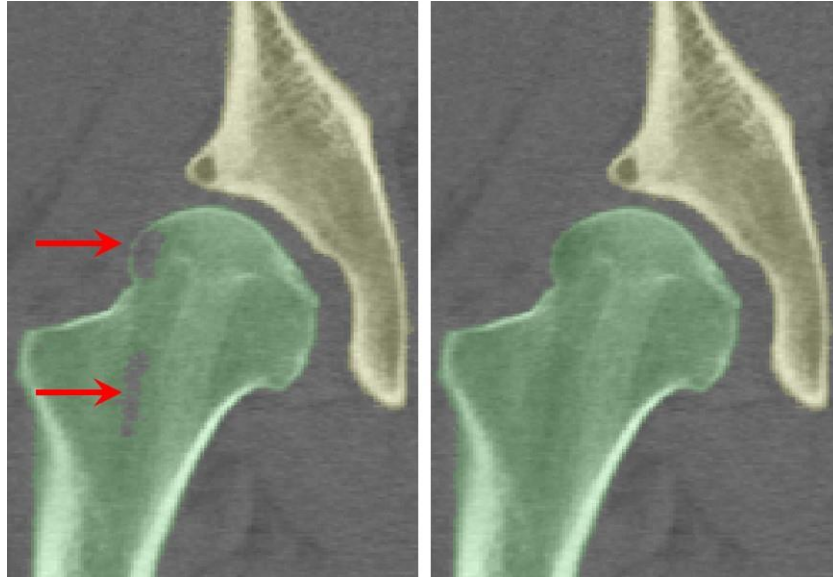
Visualization of the pelvic CT scan in ITK-Snap. The watershed algorithm accurately distinguishes between the bony geometries, and each bone is segmented as a different color. However, some holes in the segmentation (as indicated by arrows) remain due to similar attenuation values between the cancellous bone and soft tissues (left). Minimal manual intervention is required to obtain a complete and accurate segmentation (right).
